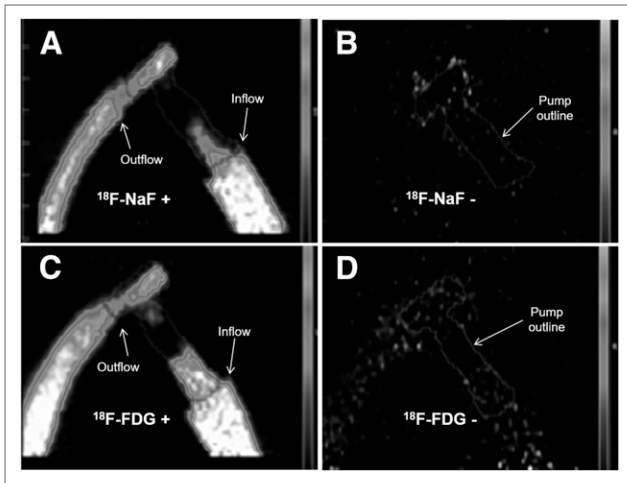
Cross-sectional PET images of MVAD® pump during circulation of $^{18}\text{F-NaF}$ (A) and $^{18}\text{F-FDG}$ (C) and after loops were drained to determine the amount of residual $^{18}\text{F-NaF}$ (B) and $^{18}\text{F-FDG}$ (D).
